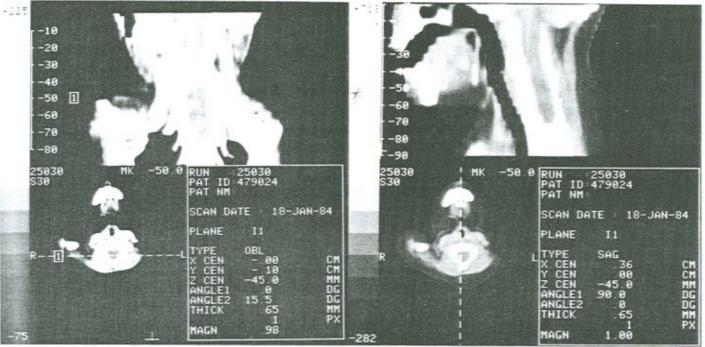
(a and b) Coronal (a) and sagittal (b) reconstructions of a contrast-enhanced CT scan of the upper thoracic and cervical spine of Case 2. There is complete obstruction of the contrast medium due to gross spinal cord enlargement with no flow proximal to the T1 level. In the lower cervical region no contrast medium can be seen, but the cervical spinal canal is enlarged. These findings are consistent with an intramedullary expansile lesion.
